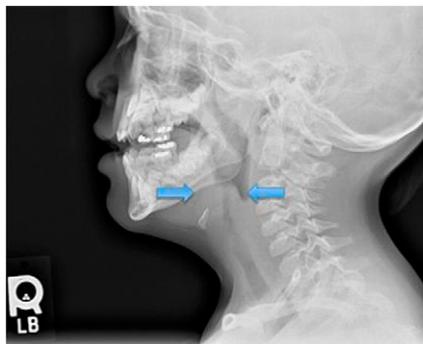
Lateral neck radiograph showing thickened epiglottic folds and poorly defined epiglottis, representing the classic “thumbprint sign.”
